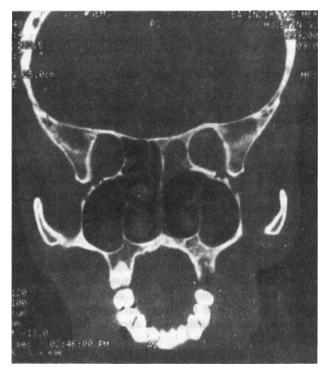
Postoperatif HRCT
